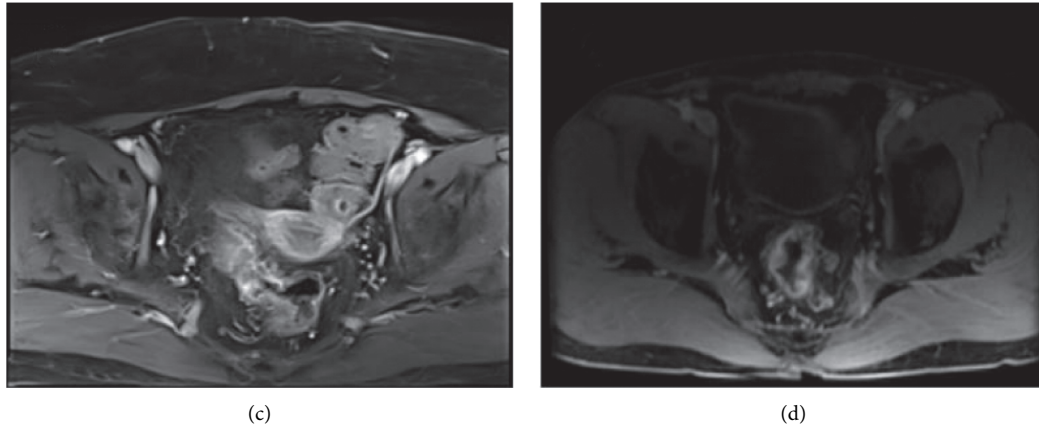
MRI image of patients with RC. (a) The patient was in stage T1 RC with high signal submucosa below the lesion, and without involvement of muscularis propria. (b) The patient was in stage T3 RC with muscularis propria and perirectal adipose tissue, but not mesorectum and fascia. (c) The patient was in stage N1 RC, and with lymph node metastasis. (d) The patient was in stage N2 RC with bilateral lymph node metastasis.
